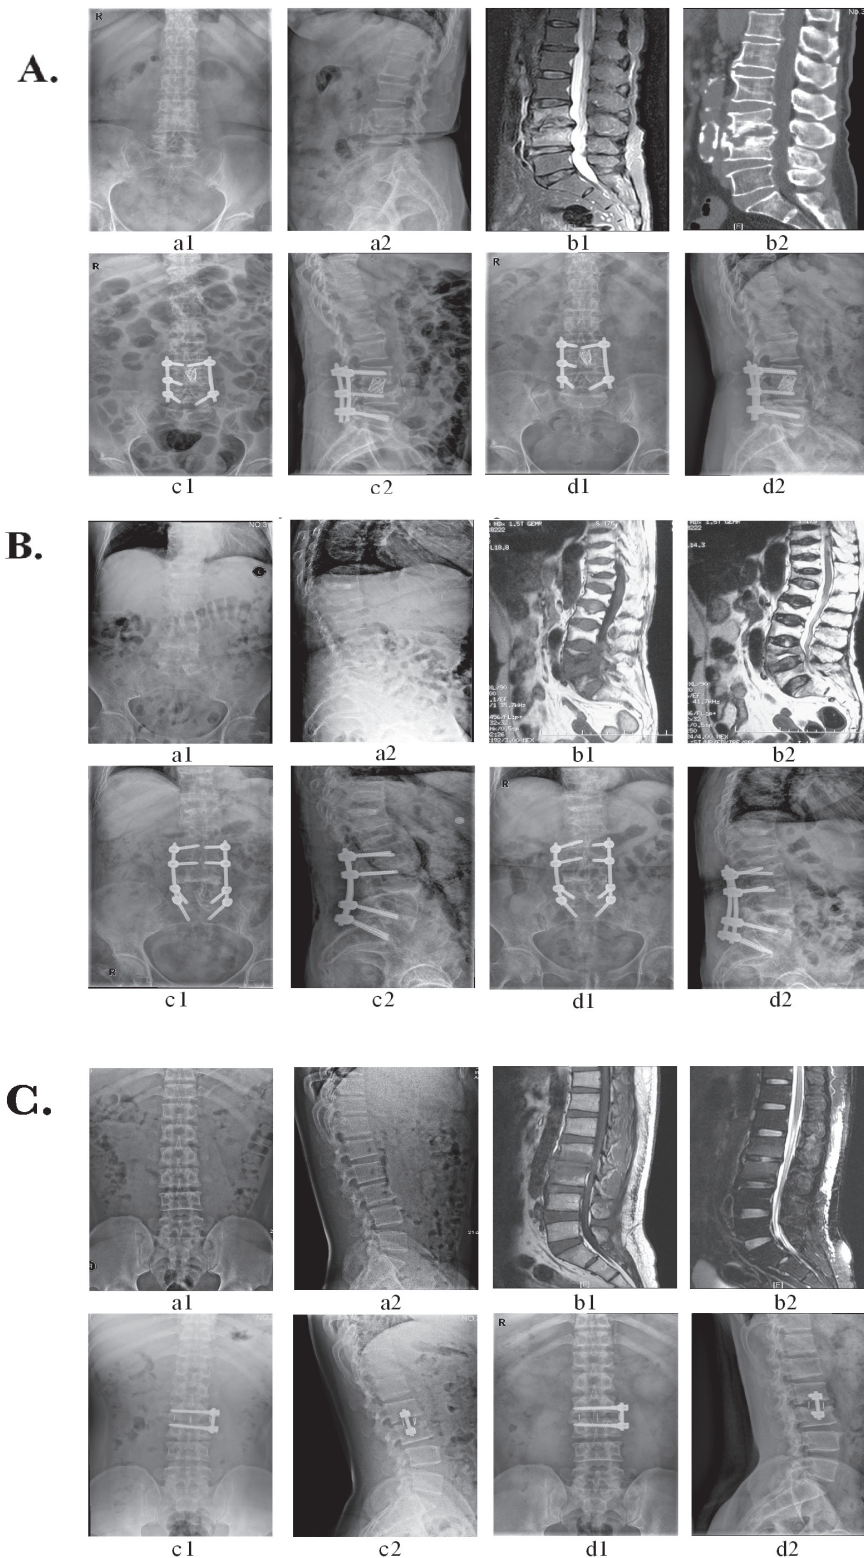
A) A 60 year old woman with spinal tuberculosis in L3-L4 B) A 79 year old female patient presented with low back pain due to destructive spinal tuberculosis at L4-L5 with a mild paravertebral abscess. C) A 36 year old male diagnosed with L2-L3 spinal tuberculosis. A titanium (A) (OR: Autologous bone grafting (B), Cage (C)) were instrumented anteriorly, and correction of kyphosis deformity was obtained after posterior percutaneous pedicle screws fixation (A, B) (OR: Lateral pedicle screws fixation (C)). Preoperative a1, a2 X-ray radiographs (Anterior and Lateral position) and b1, b2 sagittal MRI or CT, and c1,c2 postoperative X-ray radiographs and d1, d2 one year follow up X-ray radiographs.
